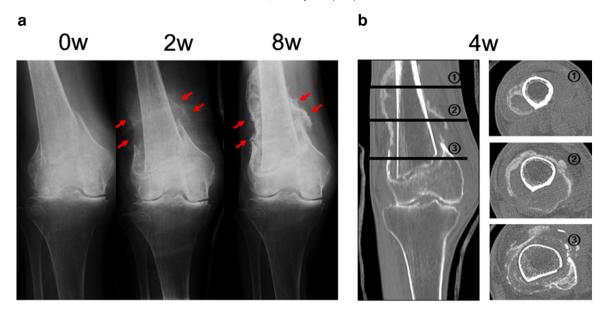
Case 1. An 88-year-old woman who sustained a supracondylar fracture of the right femur. (a) Anteroposterior radiograph of the right knee soon after the fracture, and 2 weeks and 8 weeks after initiation of teriparatide therapy. Obvious callus formation was visualized around the fracture site was observed at 2 and 8 weeks after treatment (arrow). (b) CT scan of the right knee taken 4 weeks after initiation of teriparatide therapy.
